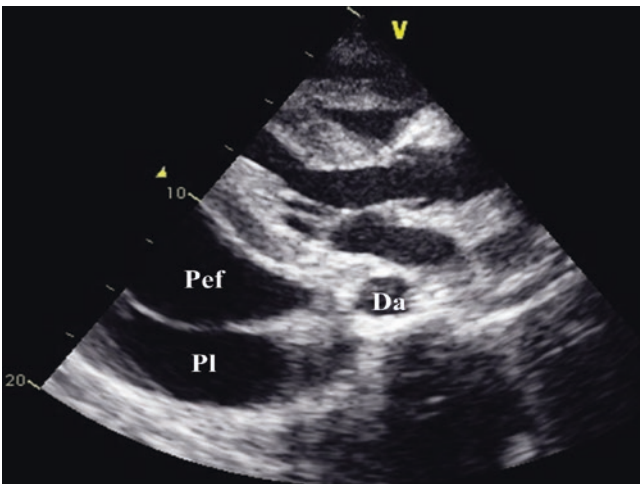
Pericardial effusion and pleural effusion in the parasternal long axis view. Pericardial effusion can occasionally be confused with left pleural effusion, right pleural effusion, ascites, and pericardial fat. In this patient, a large pericardial effusion (Pef) is seen as an echo free space behind the inferolateral wall of the left ventricle. Left pleural effusion (PI) is also seen. Note the position of the descending aorta (Da) behind the bright line of the pericardium. See also Video 18.3
